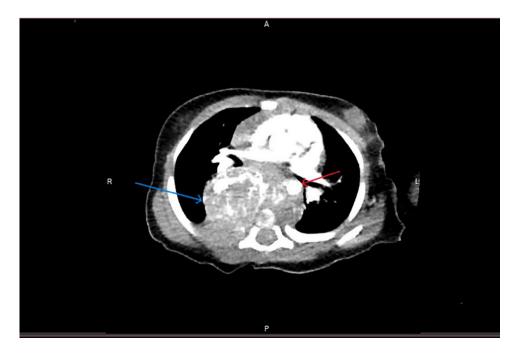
Computed tomography scan of chest (axial view) shows neuroblastoma (blue arrow) and descending aorta (red arrow).
